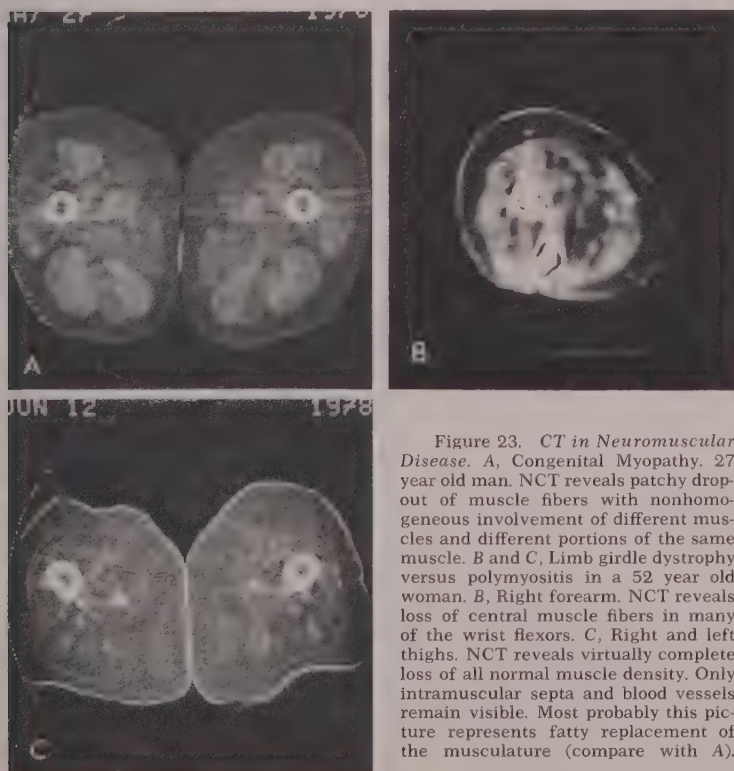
CT in Neuromuscular Disease. A, Congenital Myopathy. 27 year old man. NCT reveals patchy dropout of muscle fibers with nonhomogeneous involvement of different muscles and different portions of the same muscle. B and C, Limb girdle dystrophy versus polymyositis in a 52 year old woman. B, Right forearm. NCT reveals loss of central muscle fibers in many of the wrist flexors. C, Right and left thighs. NCT reveals virtually complete loss of all normal muscle density. Only intramuscular septa and blood vessels remain visible. Most probably this picture represents fatty replacement of the musculature (compare with A).
